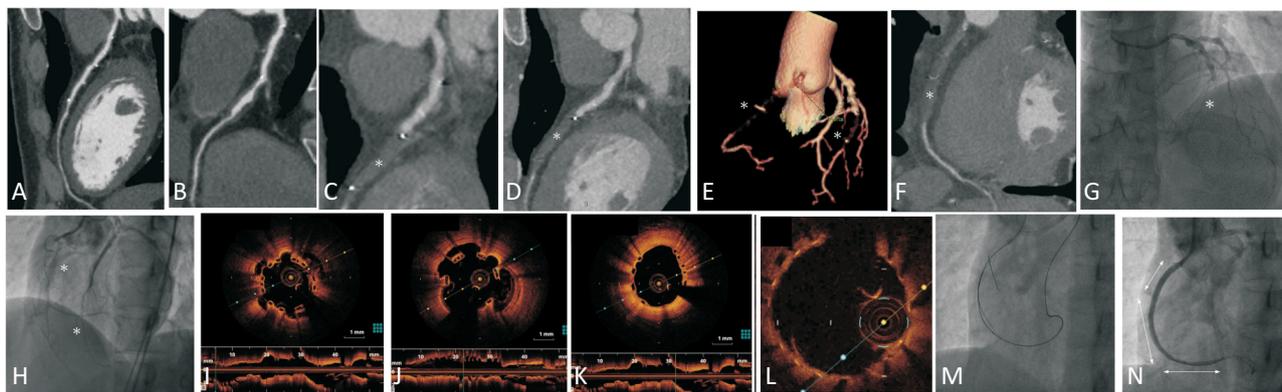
Series followed coronary images five months and twenty months after bioresorbable scaffold deployment (A to H) and followed intracoronary images twenty months after bioresorbable scaffold deployment (I to N). (A) Five months later, followed CTA revealed patent LAD over segment 6 and 7. (B) RCA was also patent after previous BRS deployment. (C, D) Twenty months later, there was total occlusive segment 7 of LAD (aster) under CTA. (E) Three-dimensional coronary reorganized angiography disclosed double total occlusive RCA and middle LAD (aster). (F) CTA revealed total occlusive RCA (aster). (G, H) CAG presented double total occlusion over LAD and RCA (aster), with collateral supply between LAD septal branches and RCA. (I, J) Previous treated segment 7 presented with struts malapposition, struts floating and new-developed CAE lesions under OCT. (K) Segment 6 was patent, and intervention was not done. (L) After recanalization of LAD with one DES deployed over segment 7, OCT was done, and stent attached well to the vessel wall. (M) RCA was successfully recanalized via retrograde approach. (N) Three DES (2.25 mm × 28 mm, 3.0 mm × 28 mm, 3.5 mm × 28 mm) were deployed over RCA from distal to proximal segment. BRS, bioresorbable scaffolds; CAA, coronary artery aneurysm; CAG, coronary angiography; CTA, computed tomography angiography; DES, drug-eluting stent; LAD, left anterior descending coronary artery; OCT, optical coherence tomography; PCI, percutaneous coronary intervention; RCA, right coronary artery.
